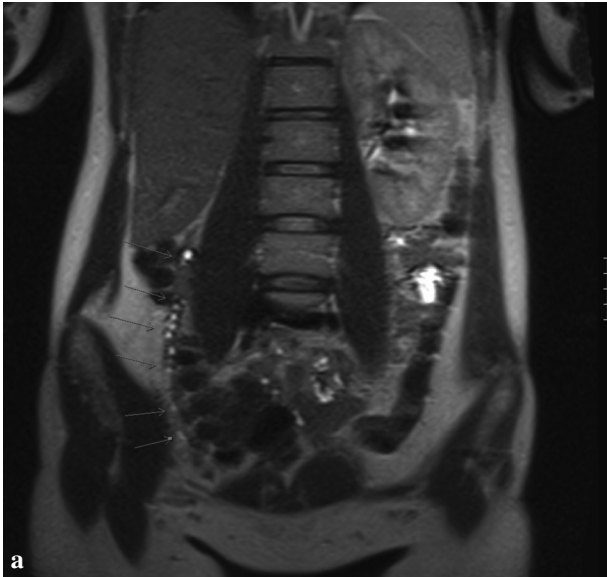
MRI: Axial (a) and coronal (b) T2 weighted image demonstrating a cluster of cysts posterior (arrow) to the hepatic flexure of the colon and anterior to the quadratus lumborum muscle. An additional finding is the absence of the right kidney.
